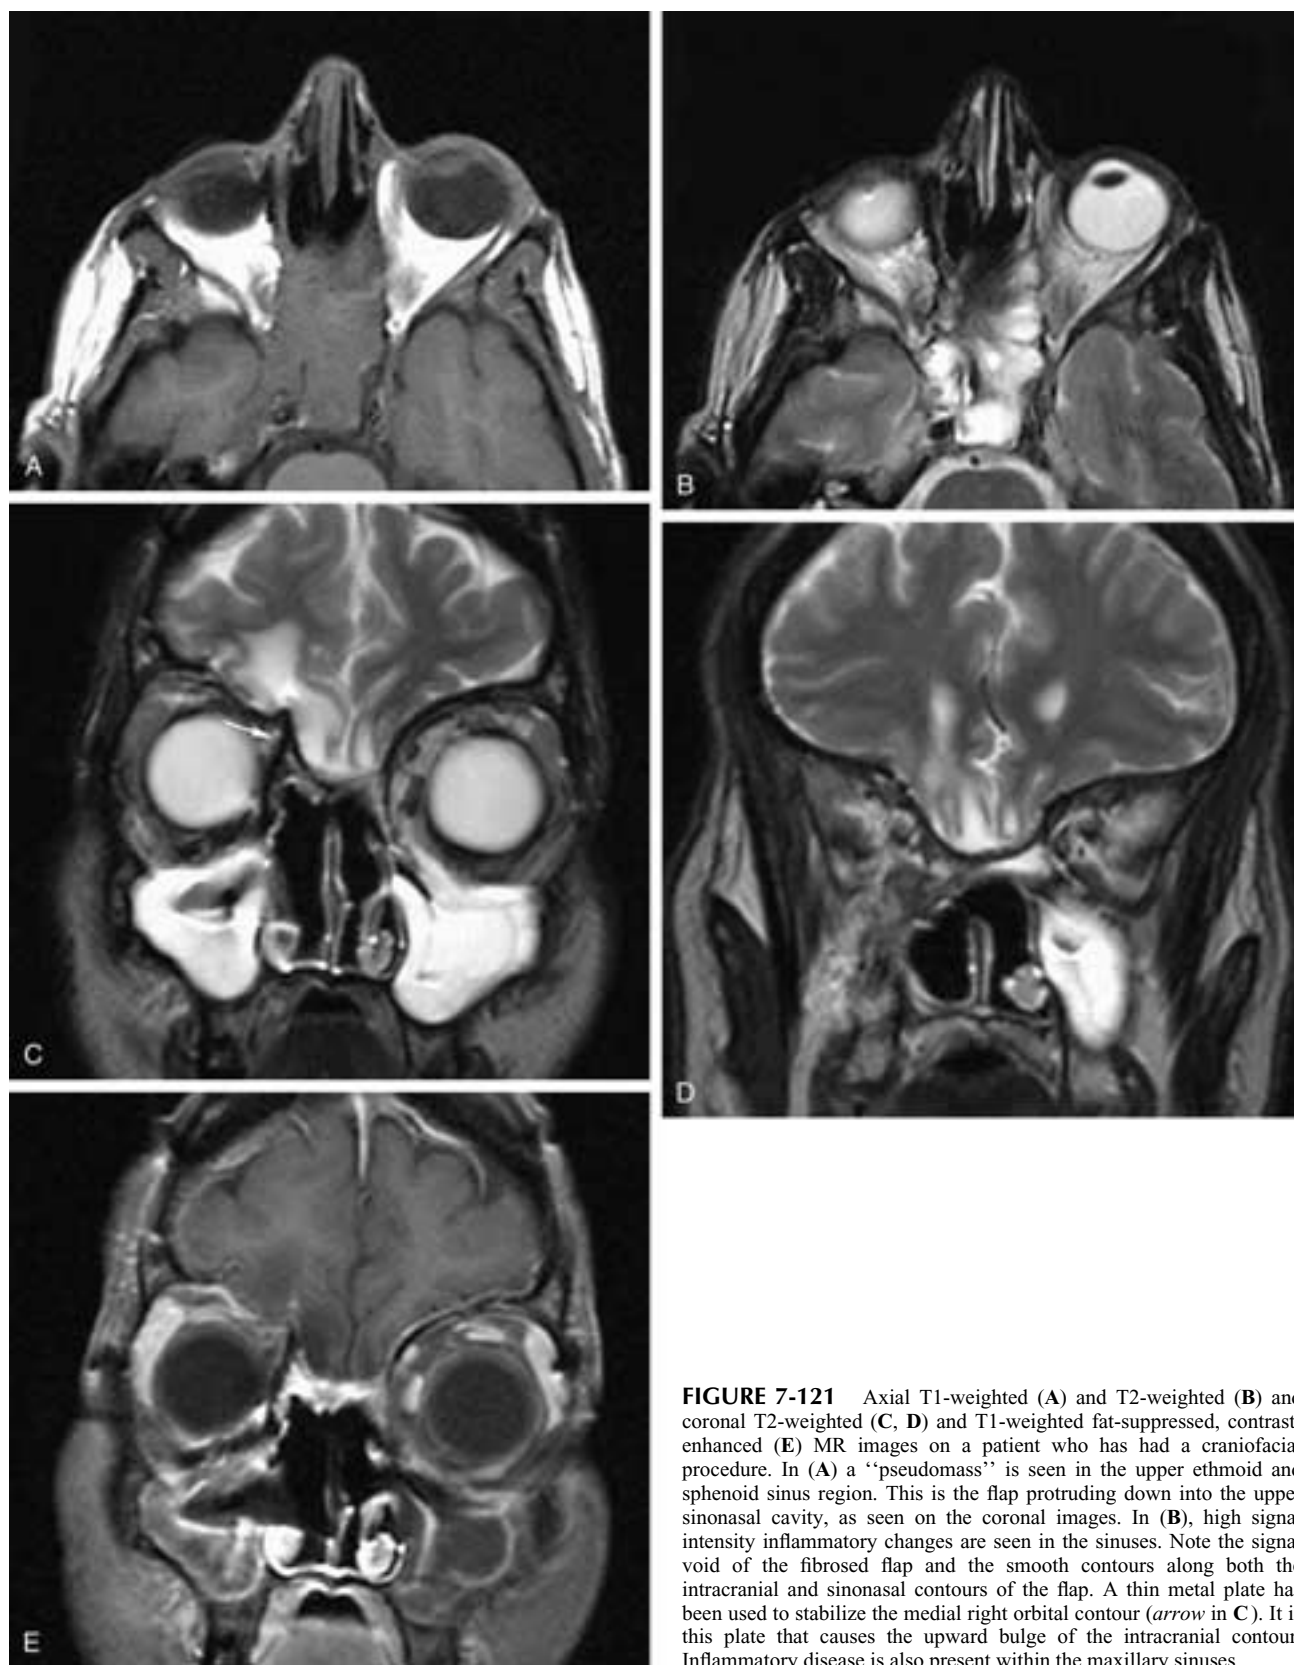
Axial T1-weighted (A) and T2-weighted (B) and coronal T2-weighted (C, D) and T1-weighted fat-suppressed, contrast-enhanced (E) MR images on a patient who has had a craniofacial procedure. In (A) a “pseudomass” is seen in the upper ethmoid and sphenoid sinus region. This is the flap protruding down into the upper sinonasal cavity, as seen on the coronal images. In (B), high signal intensity inflammatory changes are seen in the sinuses. Note the signal void of the fibrosed flap and the smooth contours along both the intracranial and sinonasal contours of the flap. A thin metal plate has been used to stabilize the medial right orbital contour (*arrow* in C). It is this plate that causes the upward bulge of the intracranial contour. Inflammatory disease is also present within the maxillary sinuses.
